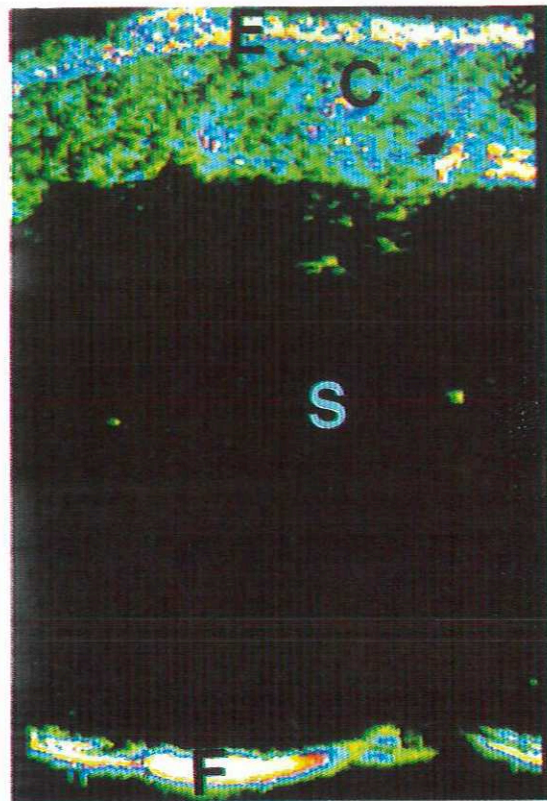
Ultrasound B-scan of healthy skin on the left flank (Case Study 1) (E: entry echo; C: corium; S: subcutaneous fatty tissue; F: muscle fascia; black arrow: reflex spots).
